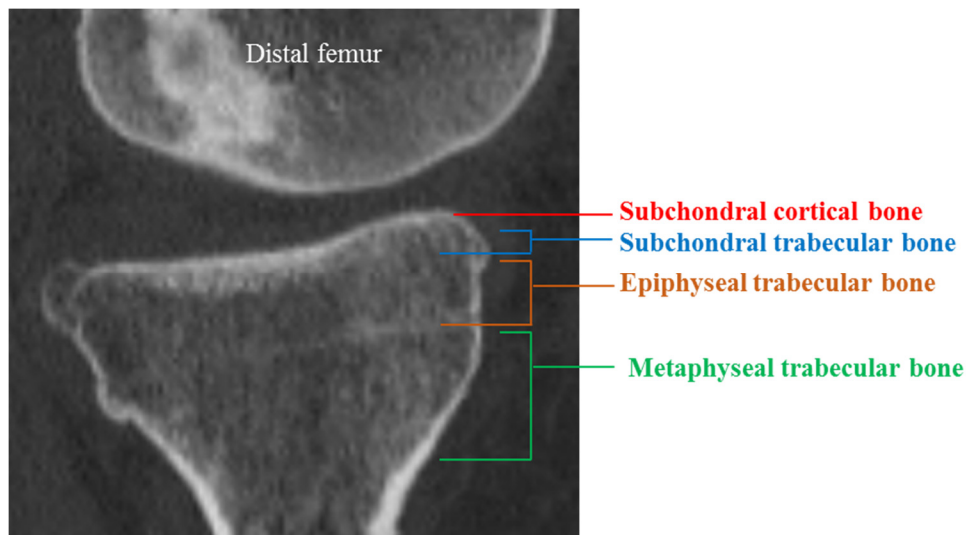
Different layers of bone including subchondral cortical, subchondral trabecular, epiphyseal trabecular, and metaphyseal trabecular are shown in a sagittal section of a CT image of the proximal tibia.
